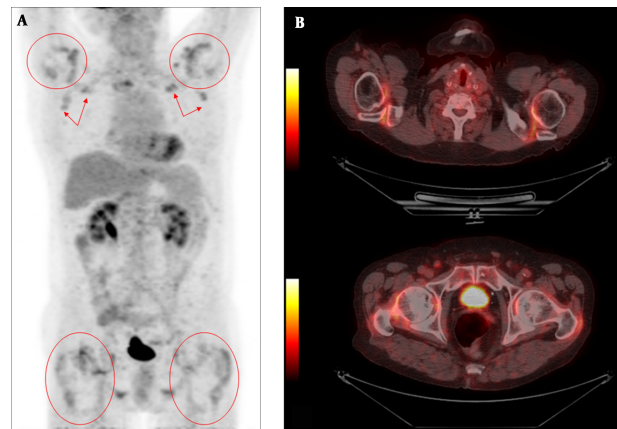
1A-1B: FDG-PET/CT Findings in a PMR Patient Initially Suspected to Have Malignant Disease
